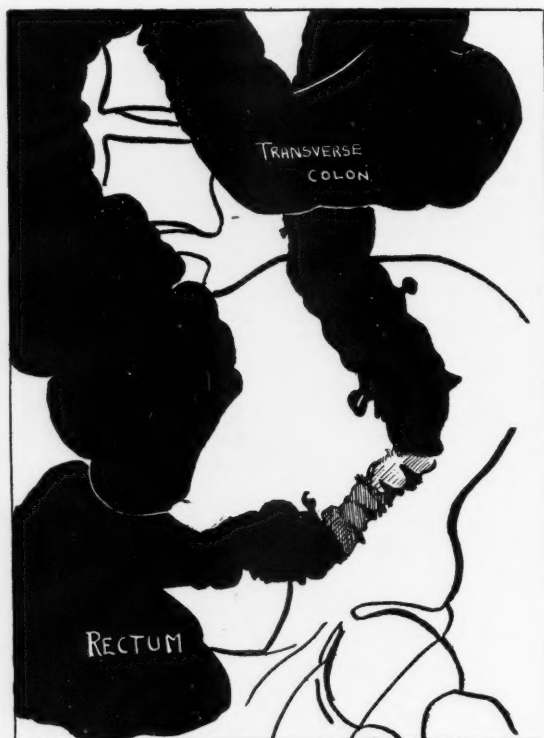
Pantograph tracing of X-ray plate showing obstructive diverticulitis. Three large diverticula also seen.
